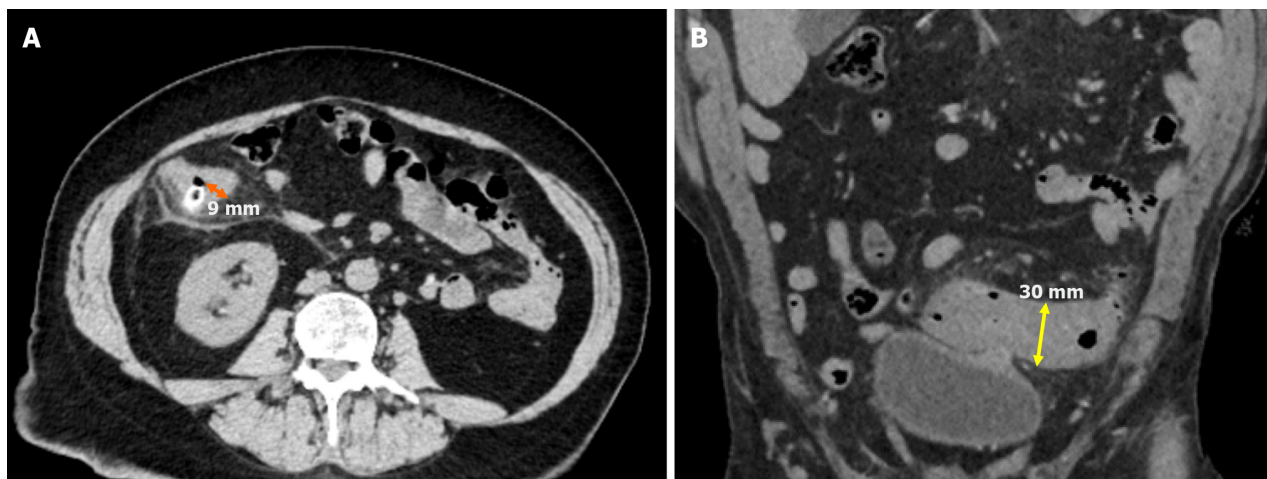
Measurement of colonic wall thickness. A: Axial non-contrast computed tomography (CT) image demonstrated right colonic diverticulitis with a distinguishable lumen. The maximum colonic wall thickness was 9 mm (orange line); B: Coronal non-contrast CT image showed sigmoid colonic diverticulitis. Since the lumen was not visualized, the serosa-to-serosa distance was measured at 30 mm (yellow double-sided arrow). Half of this distance was the estimated luminal wall thickness, calculated as 15 mm.
